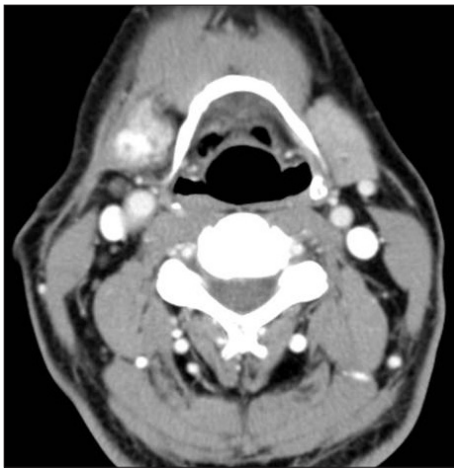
Computed tomography with contrast enhancement shows an approximately 3×3 cm sized heterogeneously lesion of the right submandibular area without regional pathologic lymph nodes.
